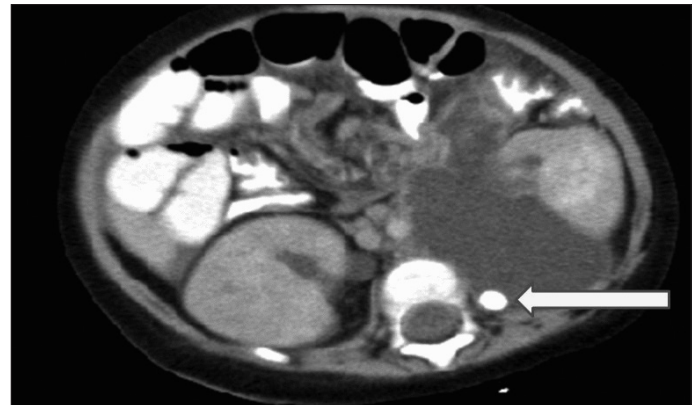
[Contrast-enhanced CT]. Arrow show left perirenal urinoma and an extruded calculus in the urinoma
